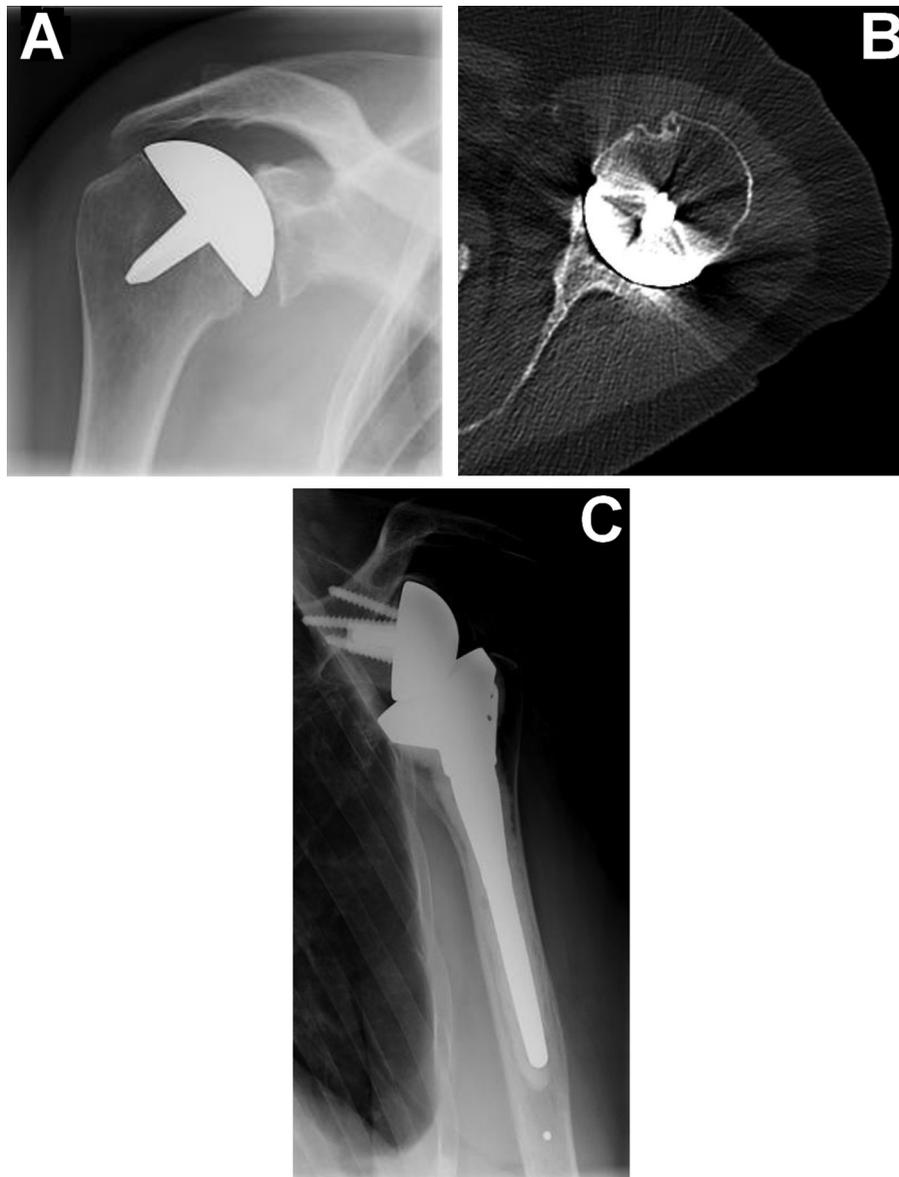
A: AP view of the left shoulder showing elevation of the humeral head due to a massive rotator cuff tear after surface replacement arthroplasty. B: CT of left shoulder (axial slice) showing centered glenoid erosion. C: follow-up X-ray after revision of the resurfacing implant with Aequalis Reverse™ (Tornier, Edina, MN, United States).
